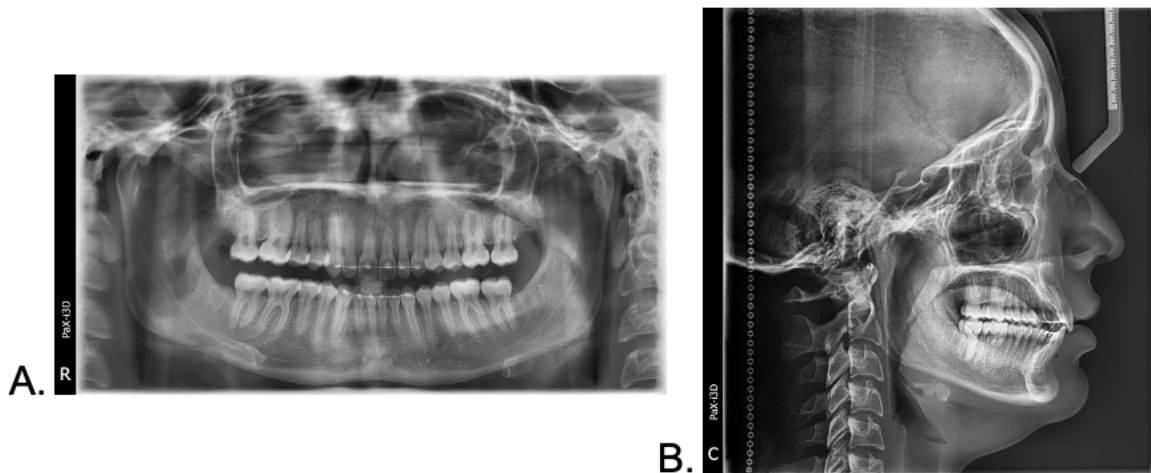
Final radiographic records. A. Panoramic radiograph. B. Lateral headfilm.
